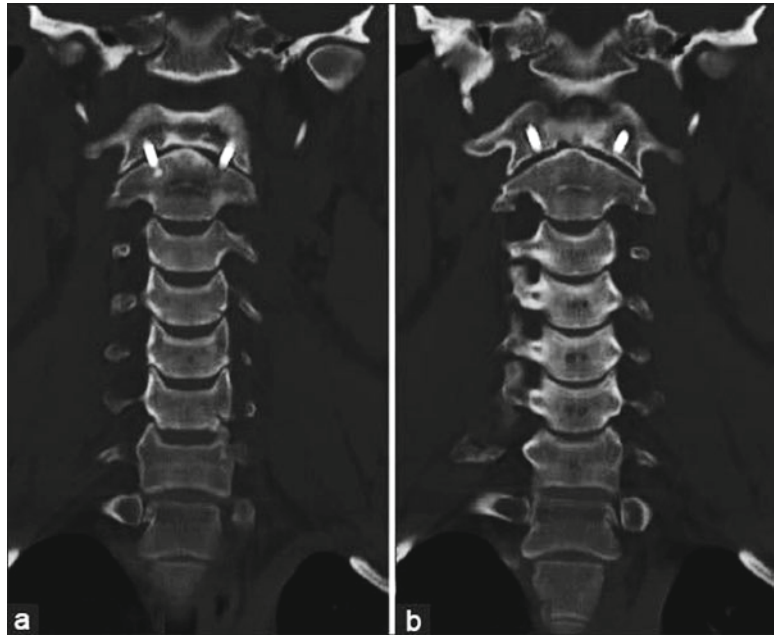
Postoperative sagittal computed tomography showing anterior atlantoaxial screw position across the C1–C2 articulation
